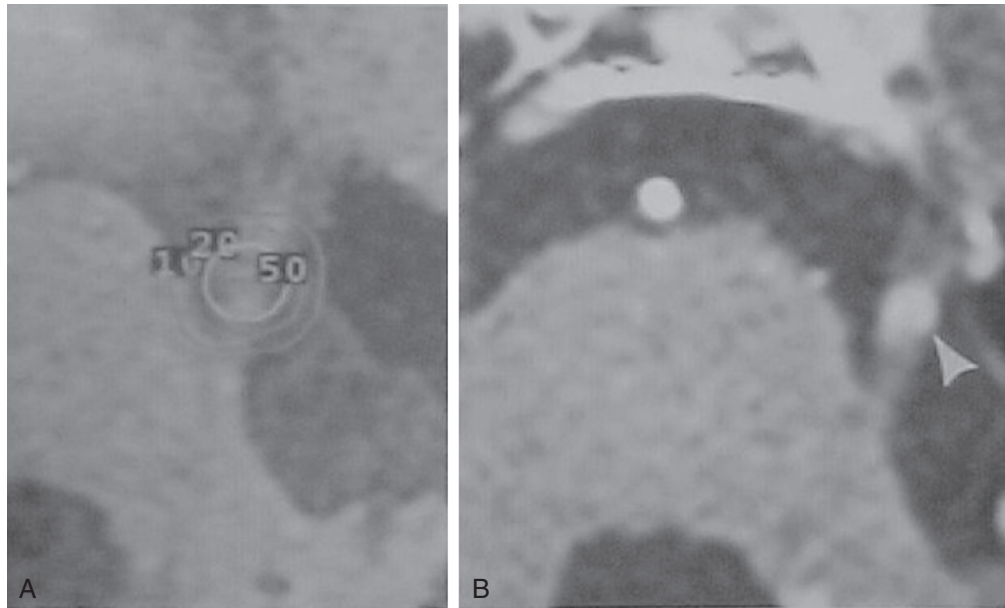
(A) Typical Gamma Knife radiosurgery dose distribution for trigeminal neuralgia targeted at the root entry zone of cranial nerve V (CN V). The prescription dose is typically 70 Gy to 90 Gy prescribed to the 100% isodose line. (B) Magnetic resonance imaging (MRI) 6 months after radiosurgery demonstrating radiographic changes on CN V.
